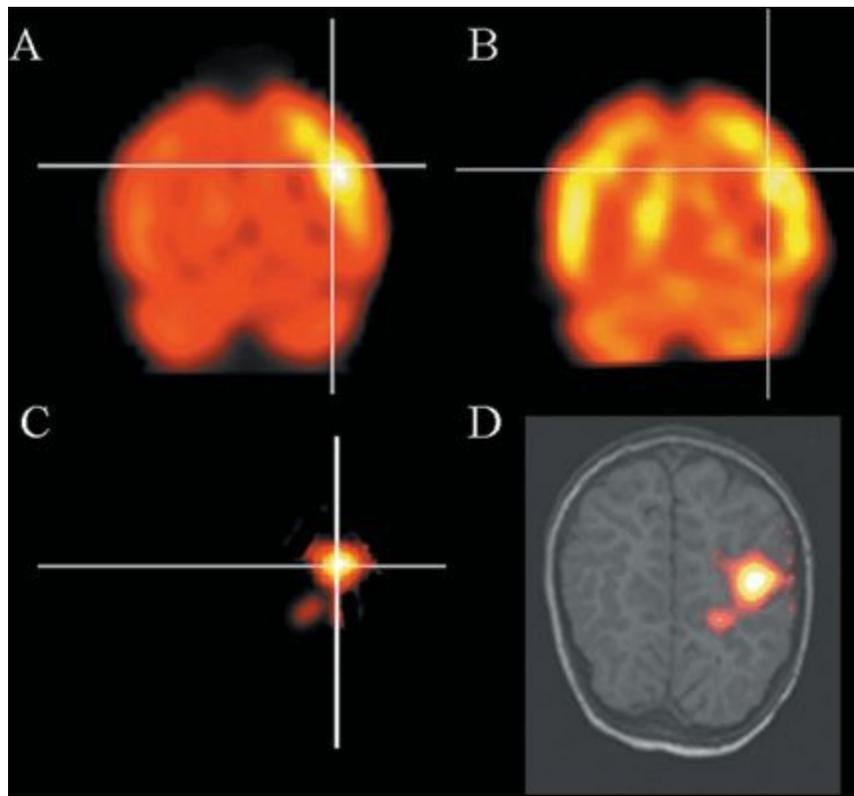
Ictal ^{99m}Tc -hexamethyl-propyleneamine oxime single photon emission computed tomography (SPECT) in a young adult with refractory partial seizures. A: Interictal SPECT. B: Ictal SPECT. C: Subtraction image of interictal from ictal SPECT. D: Subtraction SPECT coregistration with magnetic resonance image (SISCOM). Study demonstrates increased ictal perfusion in the parietal lobe. Here, the right side of the image is the left brain. Chronic invasive recording and surgery subsequently confirmed the ictal focus identified by subtraction SPECT techniques. (Courtesy of Dr. Gregory Cascino, Mayo Clinic, Rochester, Minnesota.)
